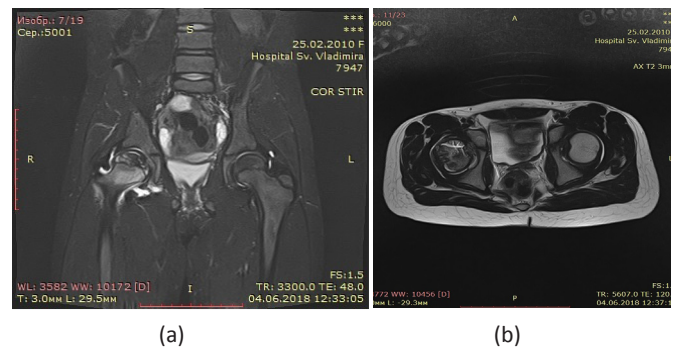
MRI, STIR, frontal view (a), T2, axial view (b) – LCPD, right side, stage III.
